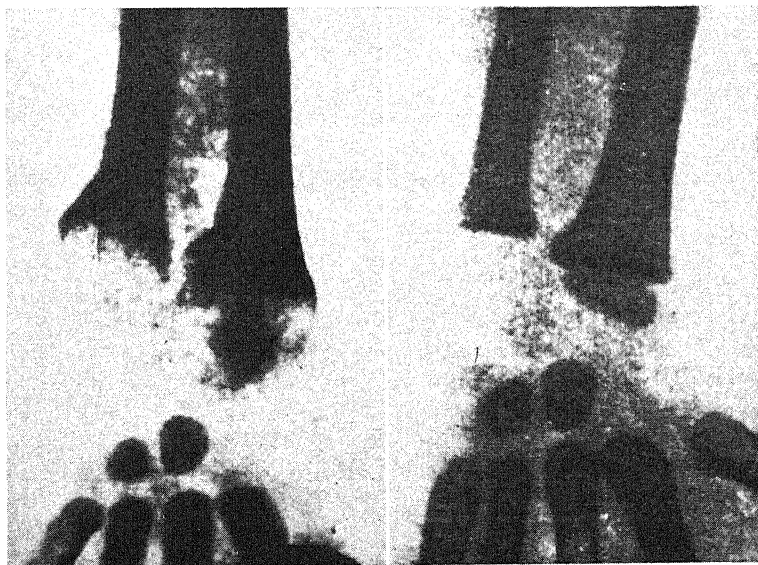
Radiograph of the wrist of a 14-month-old child suffering from rickets (left). After treatment with vitamin D the radiograph (right) showed normal calcification. (Courtesy of Professor Garrahan.)
